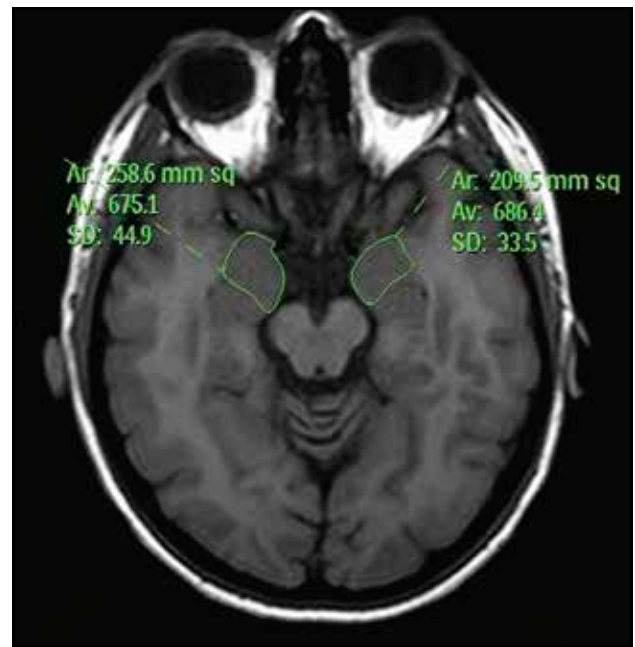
On axial FLAIR MRI scan, the corpus amygdala area is measured at maximum section as mm².
